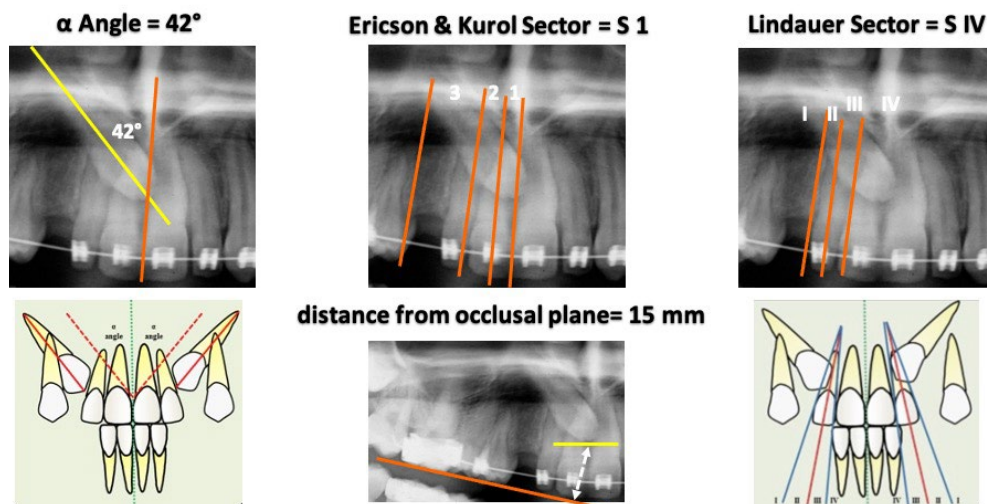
Panoramic x-ray examination.
